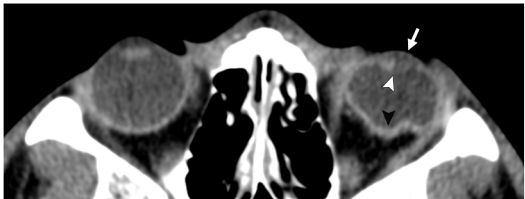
Axial CT orbits of a patient with penetrating globe injury and corneal laceration showing abnormal hypodense appearance of the left lens (*white arrowhead*) and reduced volume of the anterior segment (*white arrow*). There is also left globe rupture (*black arrowhead*).
